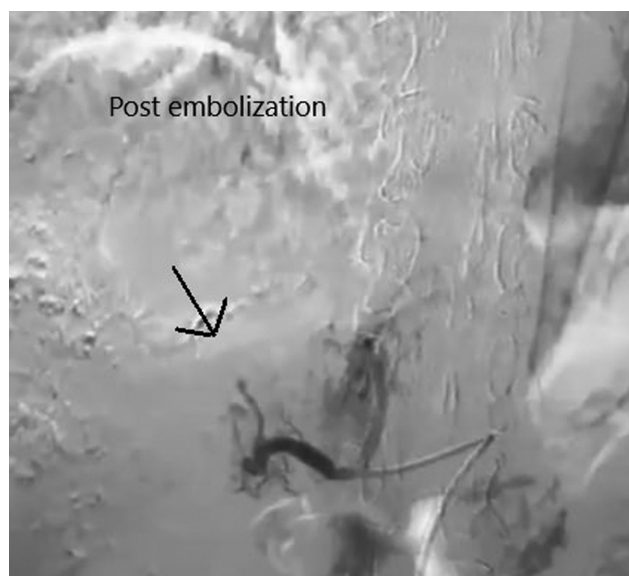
Computed tomography angiography showing tumor thrombus status after transarterial chemoembolization done using doxorubicin and lipiodol.
